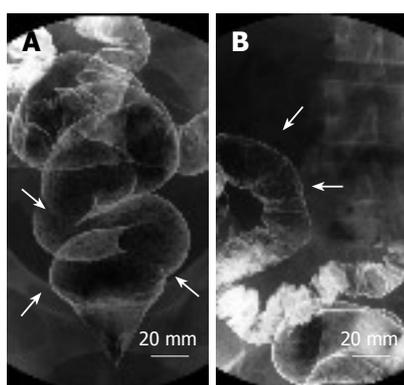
Double contrast X-ray study (A) and double contrast X-ray study (B) showing multiple small polypoid lesions in the ileum, colon and rectum.
